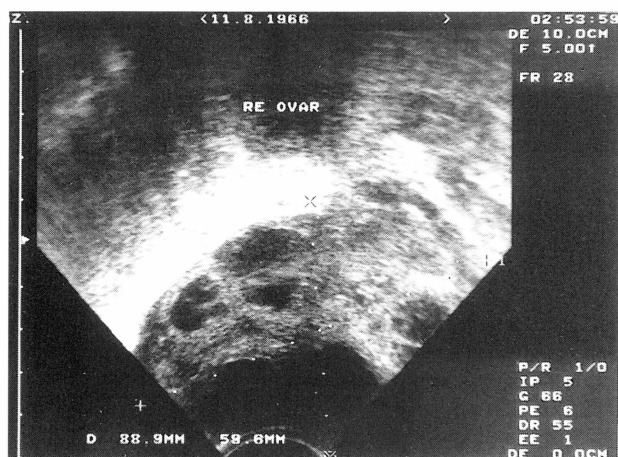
Patient 1. Vaginal sonogram showing a cystic left ovary but no free fluid.
